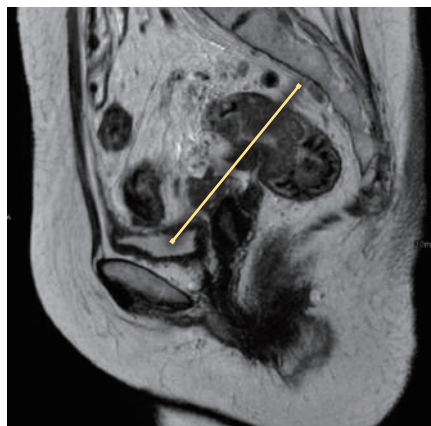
MRI image for rectosigmoid in T2W sequence (sagittal view), as upper rectal tumor across the sigmoid take-off
